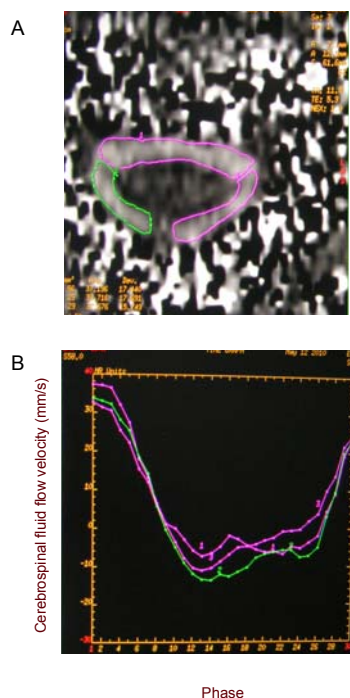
Cervical phase-contrast cine-MRI horizontal axial scanning of oscillating waveform of cerebrospinal fluid in every phase in ventral, right and left post-lateral subarachnoid space at C₂₋₃ levels.
